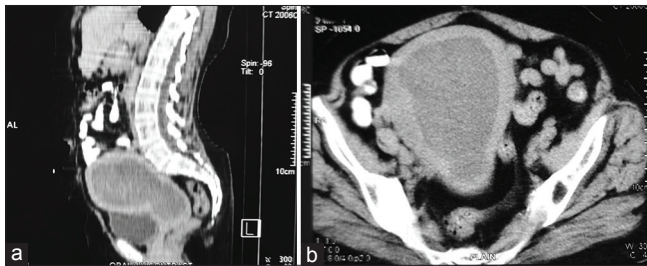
(a and b) Preoperative contrast-enhanced computed tomography pelvis axial and Sagittal view, respectively, showing large uterine mass without any appreciable lymphadenopathy
